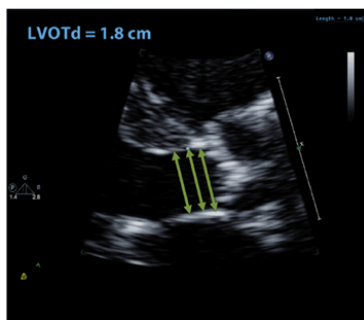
Left ventricular outflow tract diameter (LVOTd) is measured in a zoomed parasternal long-axis view in mid-systole from the white-black interface (inner-to-inner) of the septal endocardium to the anterior mitral leaflet, parallel to the aortic valve plane. Some experts prefer to measure within 0.3–1.0 cm of the valve orifice whereas others prefer the measurement at the annulus level (see text). Note that in many patients, as in this case, the LV outflow tract is relatively rectangular within 1 cm of the annulus. Green double headed arrows show the LVOTd measurement at the annulus and with different distances from it yielding identical measurements in this patient.
